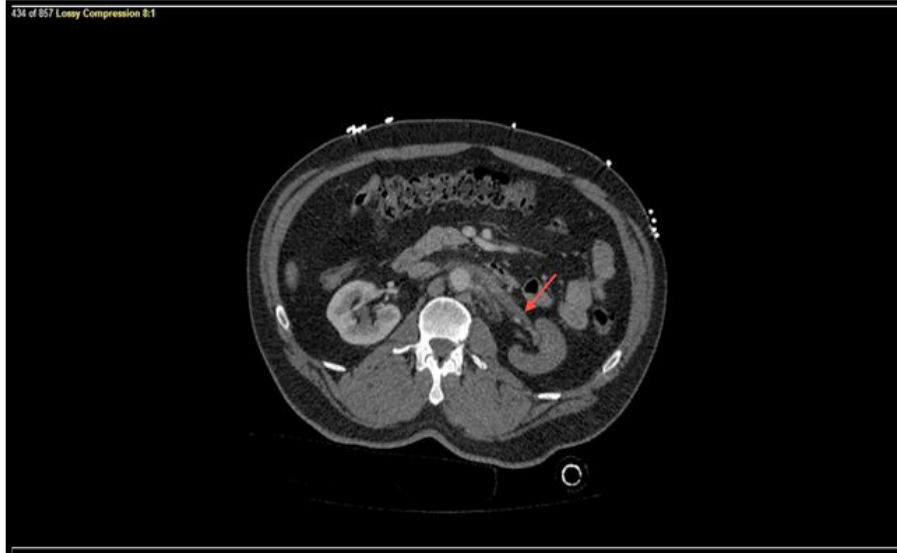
CT of Left Renal Artery Dissection and Thrombosis at initial presentation
